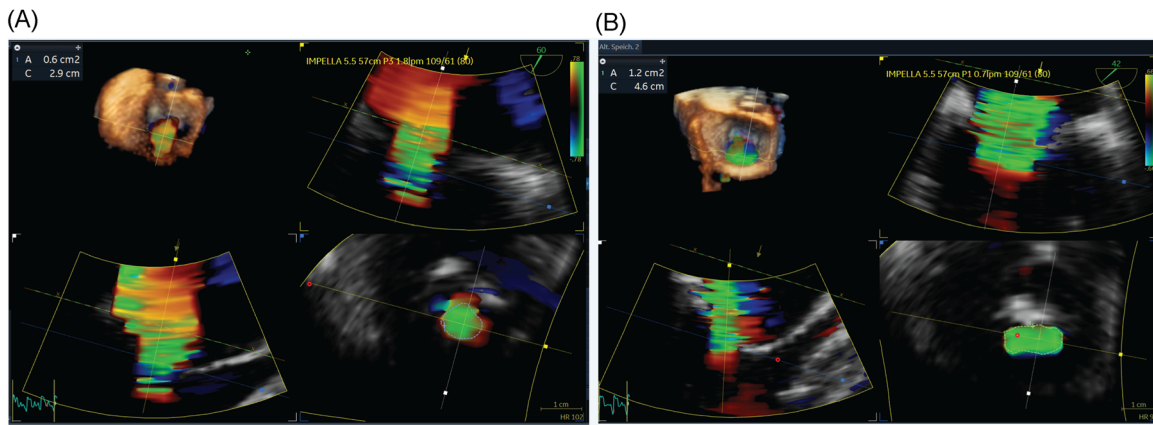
Preoperative echocardiography. (A and B) Preoperative three-dimensional transesophageal echocardiography showing the increase in effective regurgitant orifice area (EROA) after reducing the Impella 5.5 flow from P3 (1.8 L/min, EROA 0.6 cm²) to P1 level (0.7 L/min, EROA 1.2 cm²)
